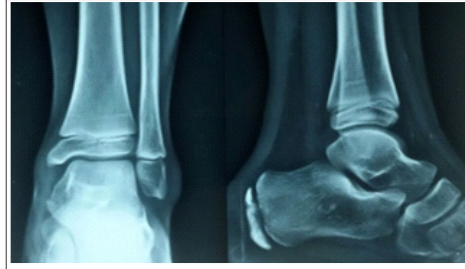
X-ray at 6 months
